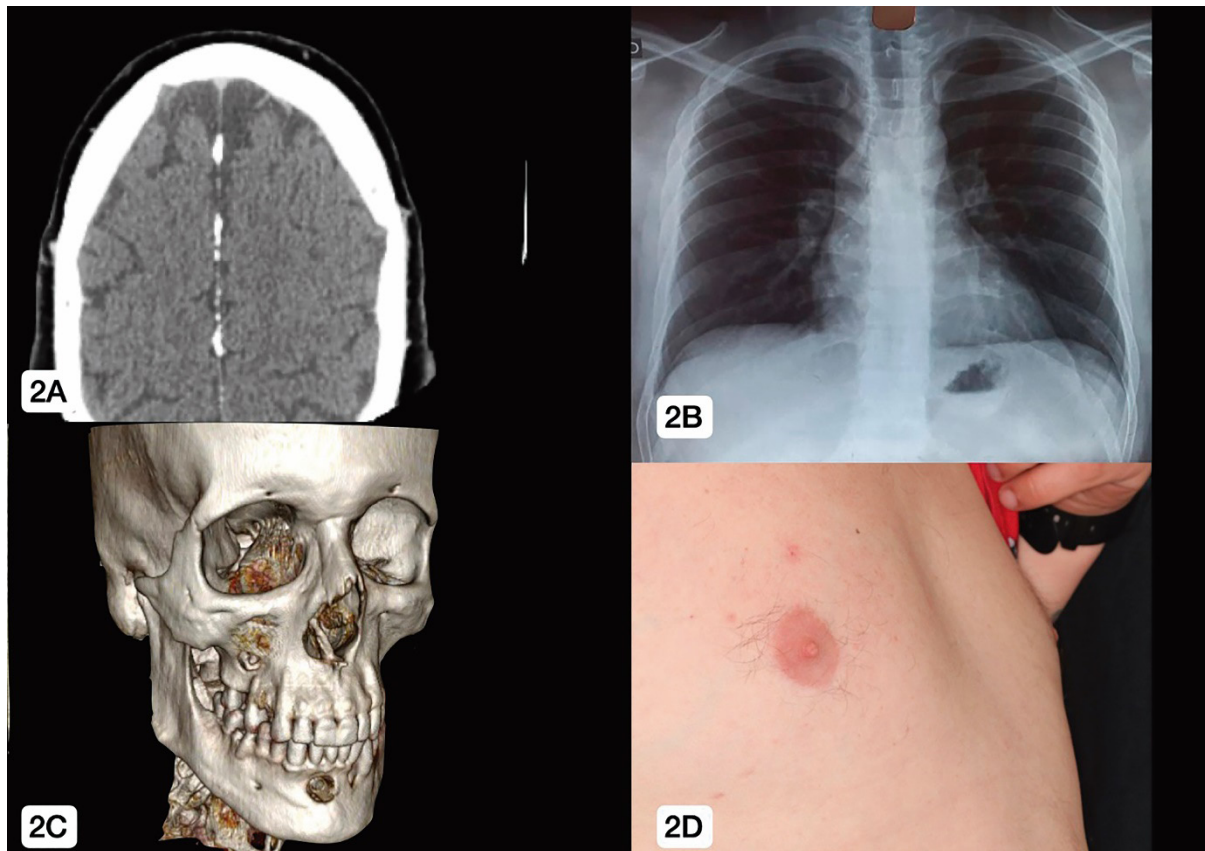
A) Axial section with cerebral falx calcification B) Anteroposterior chest x-ray C) 3D face reconstruction D) Chest *excavatum*.
